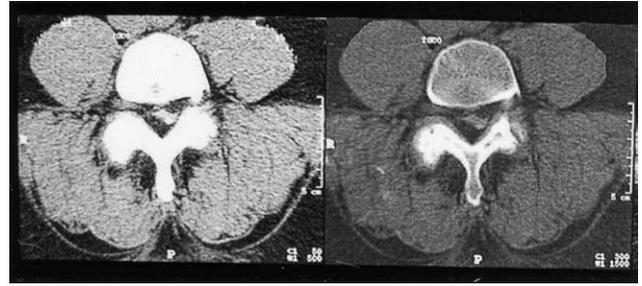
First patient: axial computed tomography myelogram views of L4–L5 shown in Fig. 1 demonstrate the extrinsic compression of the thecal sac just above the L4–L5 disc space. The compression is symmetrical and is close to water density, certainly less dense than ligamentum flavum, capsule or disc. There is an abnormal dural sac shape changed by the extrinsic pressures of the epidural lipoma.
